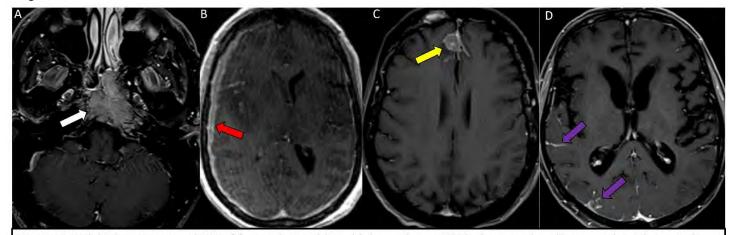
Axial T1 post contrast MRI of four patients with multiple myeloma. (A) depicts an enhancing mass along the central skull base with involvement of the clivus (white arrow). (B) depicts irregular dural enhancement along the right cerebral hemisphere (red arrow) with myeloma involvement demonstrated on biopsy. (C) depicts an enhancing, dural based mass arising along the right anterior falx (yellow arrow) consistent with a plasmacytoma. (D) depicts leptomeningeal disease in the right temporoparietal region (purple arrows) in a patient with CSF positive for multiple myeloma.
